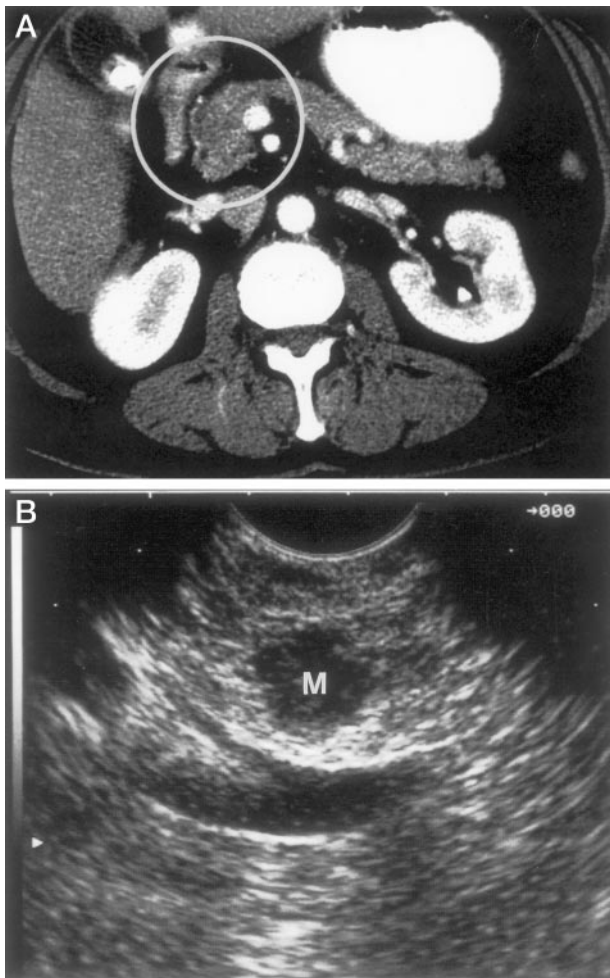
Identifying the presence of a mass on helical computed tomography (CT) and endoscopic ultrasound (EUS). (A) No tumor was identified on helical CT; however, the same patient underwent an EUS (B) and demonstrated a 1.5-cm mass (M) in the head of the pancreas. Note the interface between the mass and the superior mesenteric/portal vein confluence, suggesting no vascular invasion.
